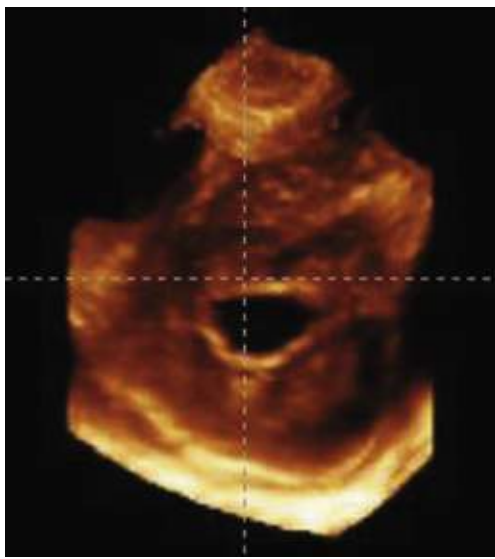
Three-dimensional imaging of rheumatic mitral stenosis, obtained by intraoperative epicardial echocardiography. Commissural fusion leaves the mitral valve with a small, circular orifice that has been likened to a fish mouth.
